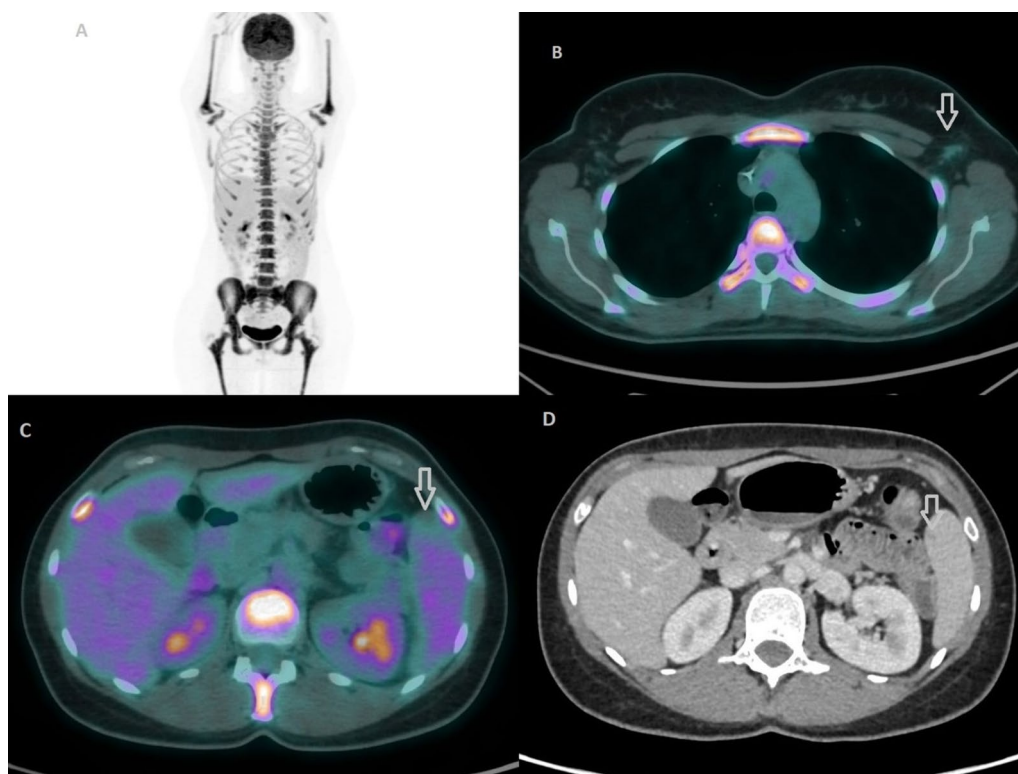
A Follow-up [¹⁸F]FDG PET/CT demonstrates marked metabolic and morphological response. B PET/CT axials show that the primary lesion has shrunk and previously involved lymph nodes no longer show abnormal uptake (arrows); notably, an intense tracer uptake was evident in the bone marrow, as for chemotherapy-induced activation. C Fused axial PET/CT shows that the previously hypermetabolic splenic lesion was no longer visible (arrow); D abdominal CE-CT also showed a meaningful reduction in size of the splenic lesion
